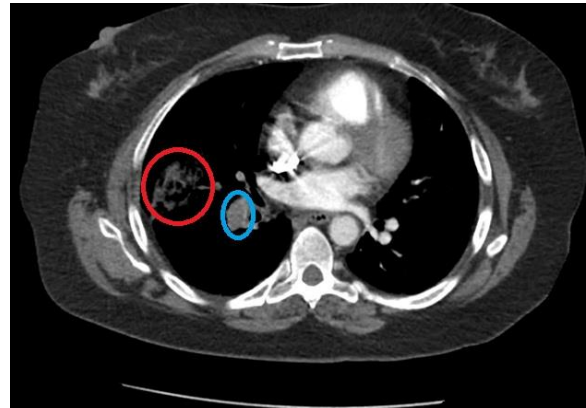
A CTA of the chest demonstrates extension of the pulmonary embolus into the right lower lobe pulmonary arterial branch (blue circle) along with a right middle lobe pulmonary infarction (red circle) which is better demonstrated in Figure 2.
